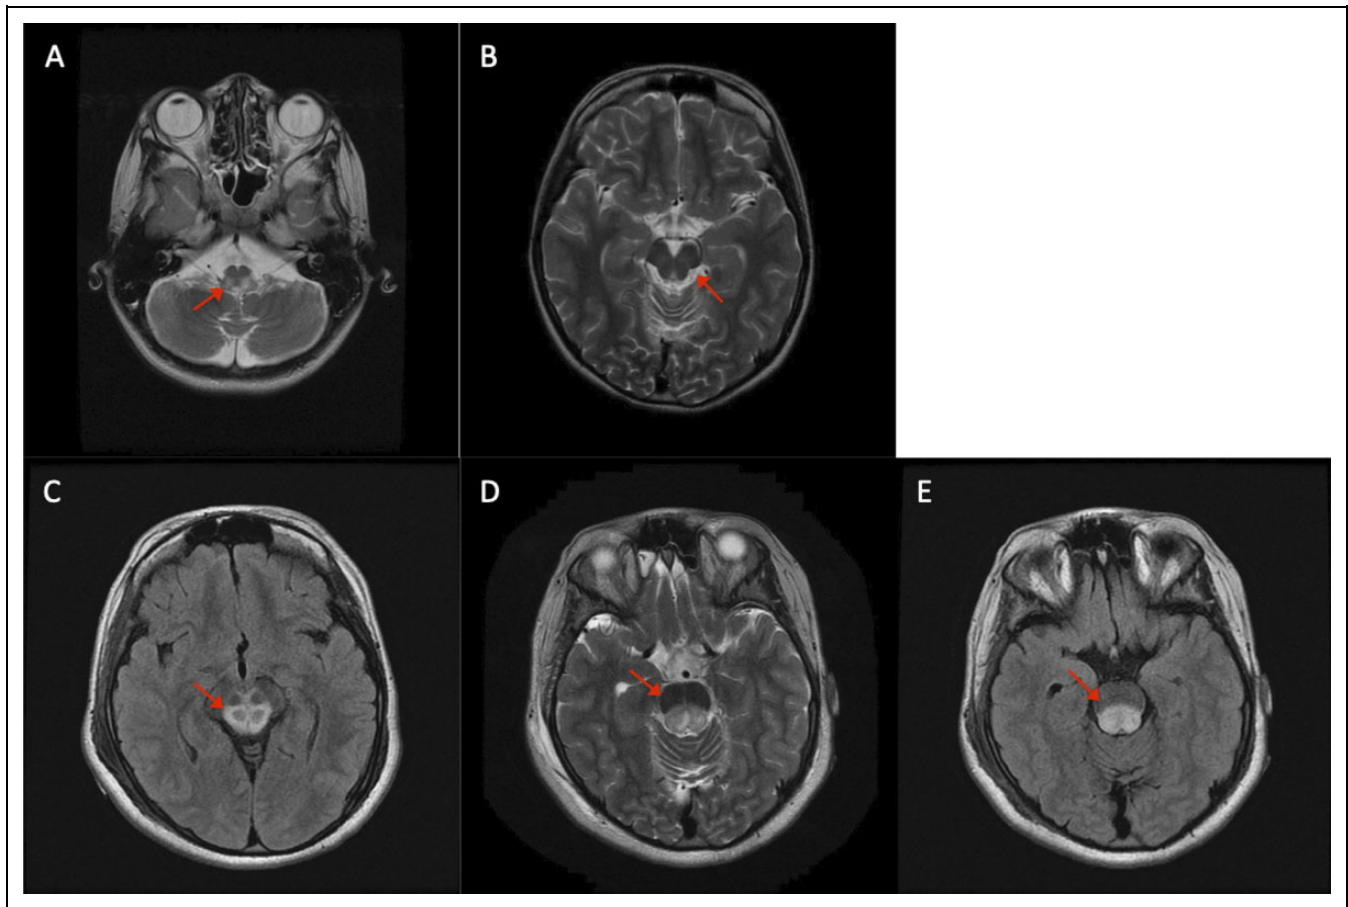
Case 2. At initial presentation, at age 10, MRI brain demonstrated symmetric T2 hyperintensities in the (A) medulla and (B) pons. Subsequent imaging at age 12 showed progression of the lesions in the (C) tectum, oculomotor nuclei, and cerebral peduncles as well as in the (D and E) pons and superior cerebellar peduncles.
